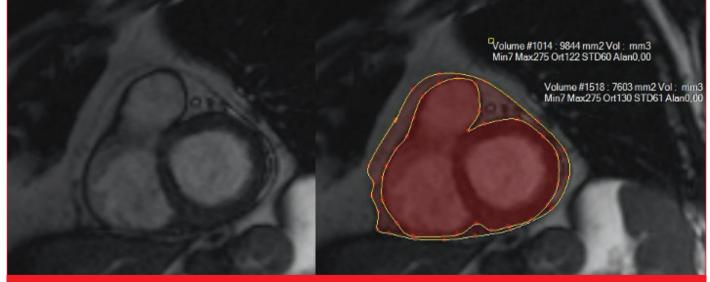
The method used for the quantification of epicardial fat volume by cardiac magnetic resonance imaging.
